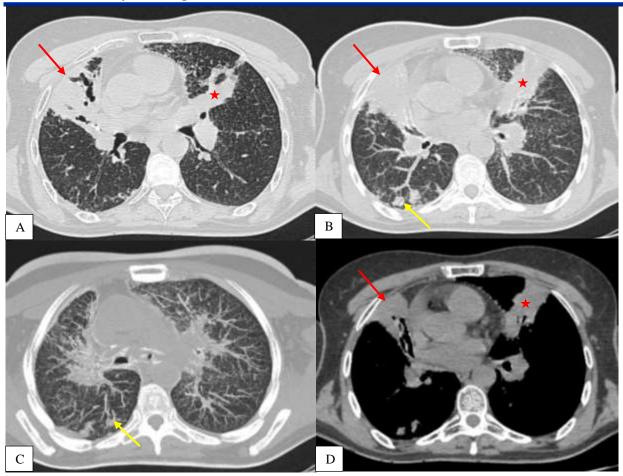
chest CT control without contrast
